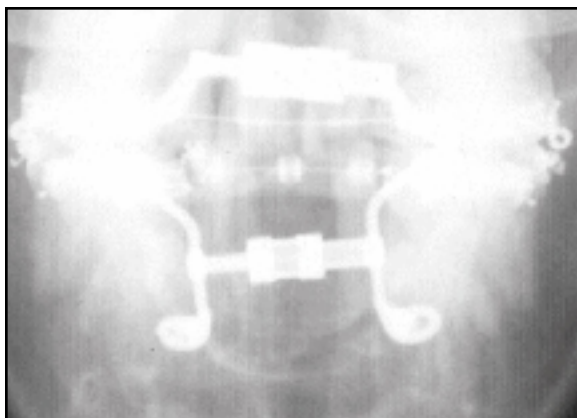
Frontal x-ray indicating non-parallel vector of distraction.
